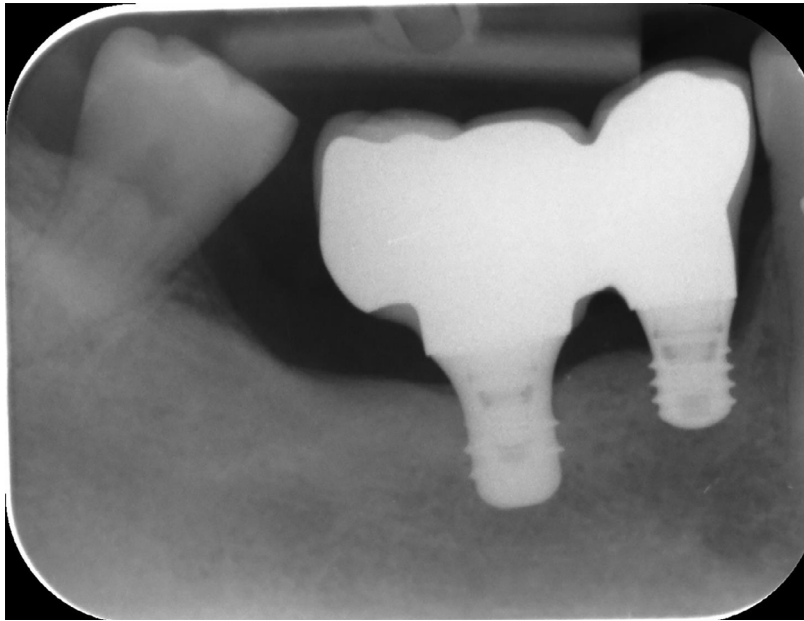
Periapical X-Ray after 7-years follow-up.*
